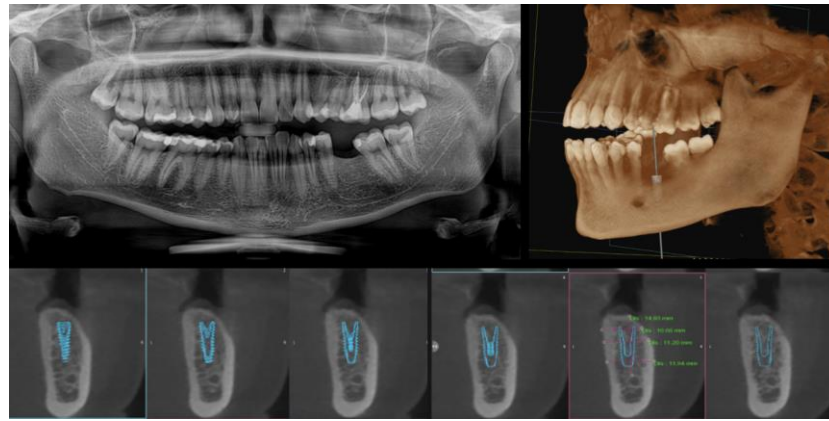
CBCT sections in sagittal, coronal, and axial planes showing available bone volume and adjacent anatomical structures.
